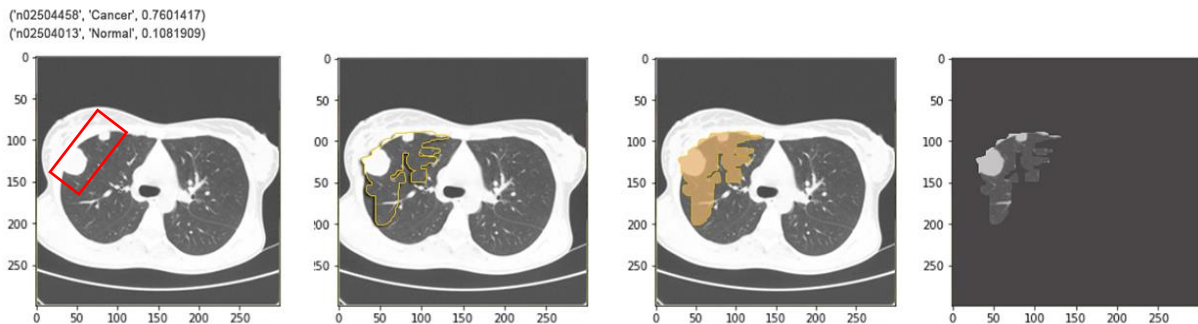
LIME result of CT image with a model of InceptionV3
